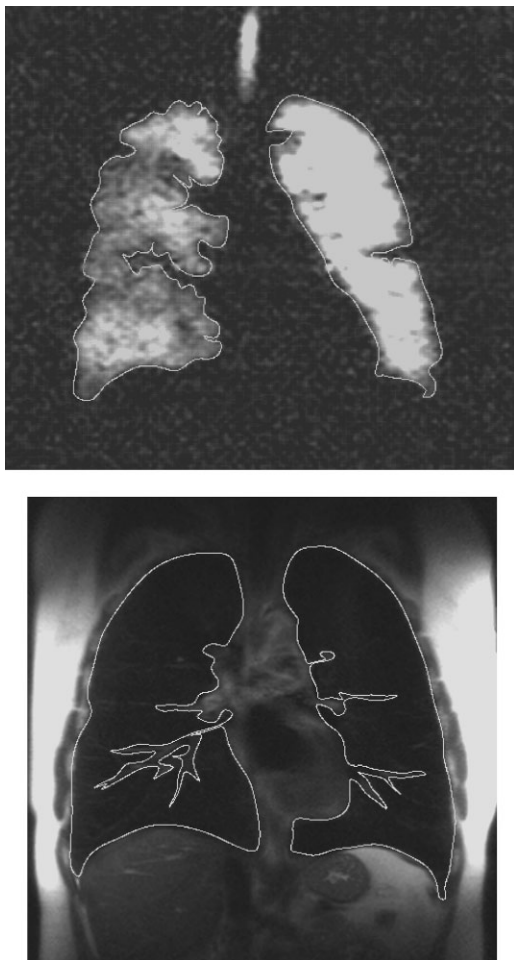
Method of quantification of ventilated lung volume. The lung is segmented in a proton MR image and the corresponding 3-He MR image is subsequently subtracted. This reveals the actual ventilated lung in this slice. Addition of slices yields the overall lung volumes.
